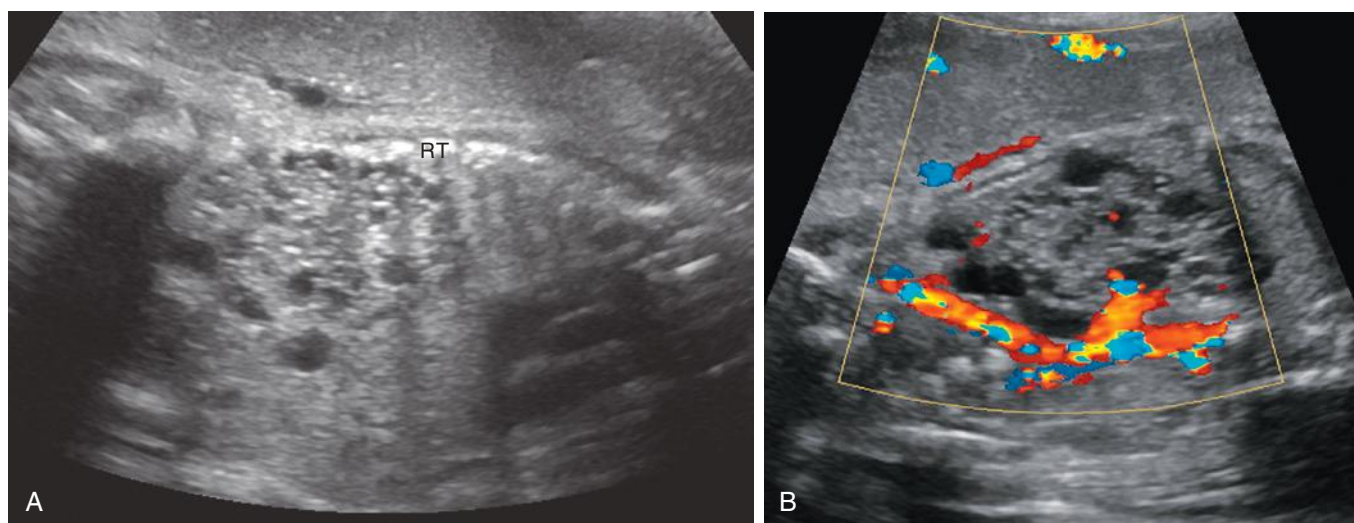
Multicystic dysplastic kidney. A, Sagittal image of the right (RT) kidney reveals multiple scattered small cysts. B, Coronal image with color Doppler interrogation shows flow at the renal hilum. The fluid-filled spaces at the periphery of the kidney are nonvascular and represent cortical cysts.
